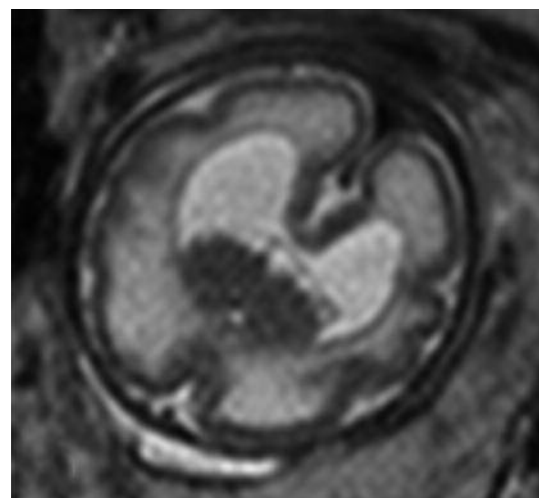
MRI axial view of lobar holoprosencephaly in a fetus of 31 weeks. Note the absent septum pellucidum, hypoplastic anterior interhemispheric fissure, non-separation of the frontal lobes, rudimentary developed anterior horns and partial fusion of the basal ganglia.
